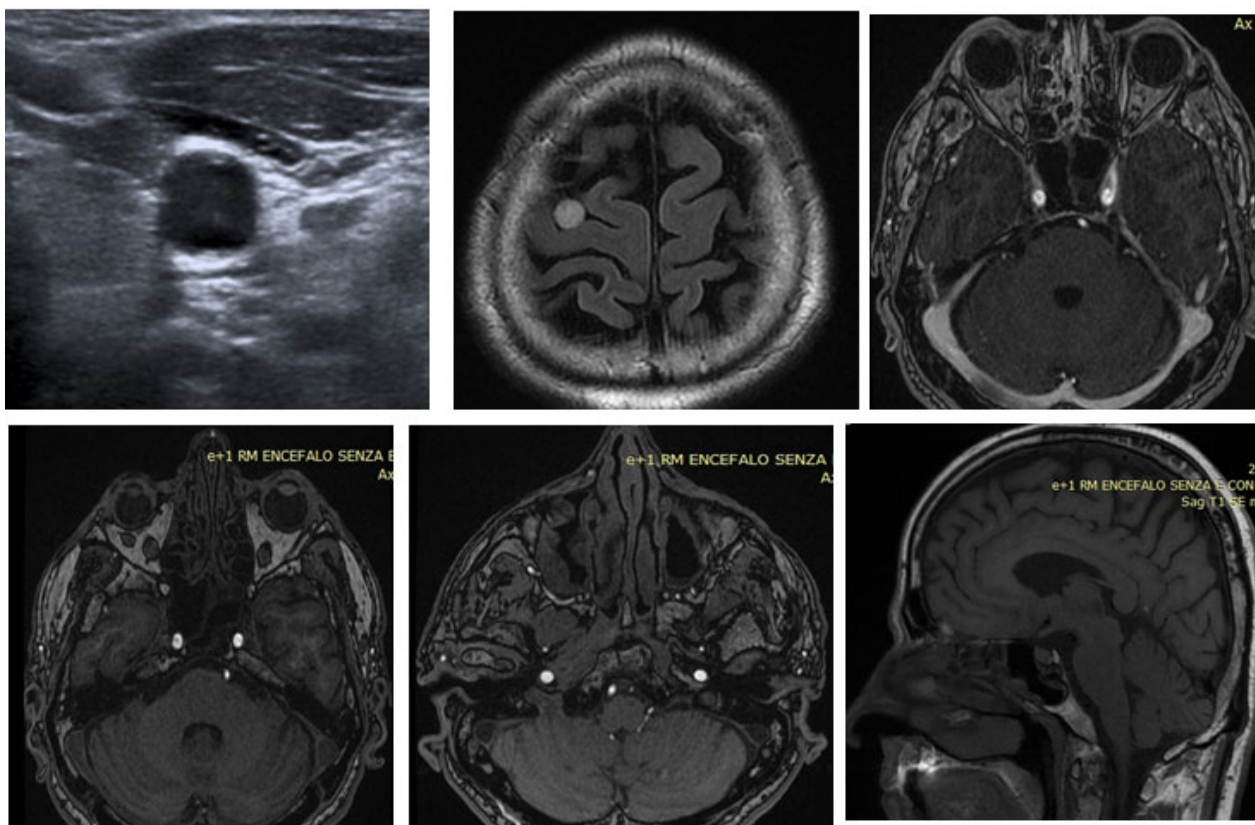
Imaging of the patient. Cervical ultrasound showed a hypoechoic thickening of the vessel wall of the left carotid artery, in the absence of atheromatous plaques . Magnetic Resonance revealed right frontal meningioma, right Schwannoma n.VII and right intraorbital cavernous angioma. Intracranial vessels appear normal
